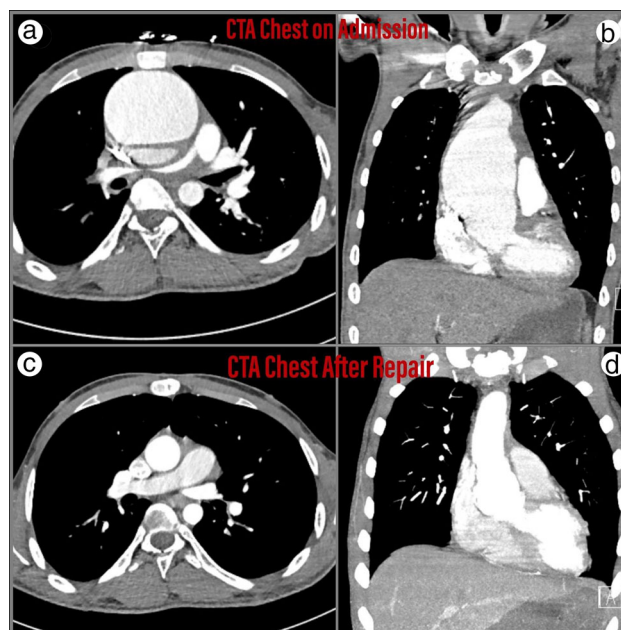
CT angiogram of the chest. (a) Anteroposterior and (b) coronal sections showing 8.8 cm fusiform aneurysm of the ascending aorta with type A aortic dissection. (c) Anteroposterior and (d) coronal views after aneurysm repair.
